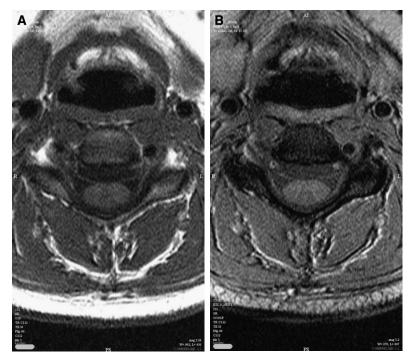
Thin-section, 3-mm, T1-weighted (T1W), spin echo (SE) versus gradient echo images of cervical spine. (A) Thin-section, T1W, SE axial images of cervical spine are fuzzy, and it is difficult to see the nerve roots. (B) Same anatomy acquired with the thin-section T1W gradient echo technique. Notice improved contrast and less cross-talk between slices. For thin slices, image quality is visibly better.
